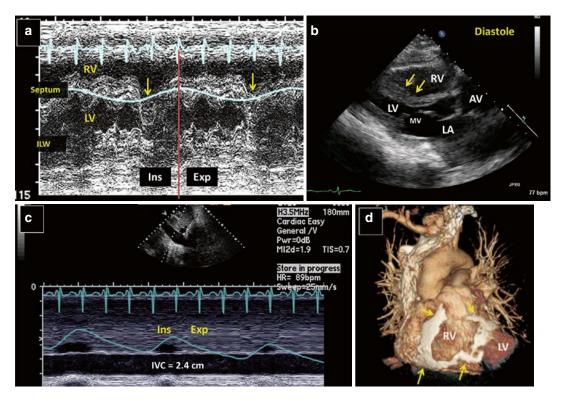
Constrictive pericarditis: echocardiographic & CT findings. Panel a: M mode recording in a patient with constrictive pericarditis demonstrates characteristic respiratory variations in the right and left ventricular chamber sizes due to abnormal interventricular septal motion phasic with respiration. Note that interventricular septum bounces (*arrow*) toward the left ventricle (*LV*) during inspiration (*Ins*) and toward the right ventricle (*RV*) during expiration (*Exp*). Panel b: Transthoracic echocardiogram in the parasternal long-axis view demonstrates characteristic diastolic septal bounce of the interventricular septum (*arrows*) toward the left ventricle during inspiration (*arrows*) toward the left ventricle during inspirates characteristic diastolic septal bounce of the interventricular septum (*arrows*) toward the left ventricle during inspiration (*arrows*) toward the left ventricle during inspiration (*arrows*) toward the left ventricle during inspirates (*arrows*) toward the left ventricle during the toward tother (*arrows*) toward the left ventricle during toward t
